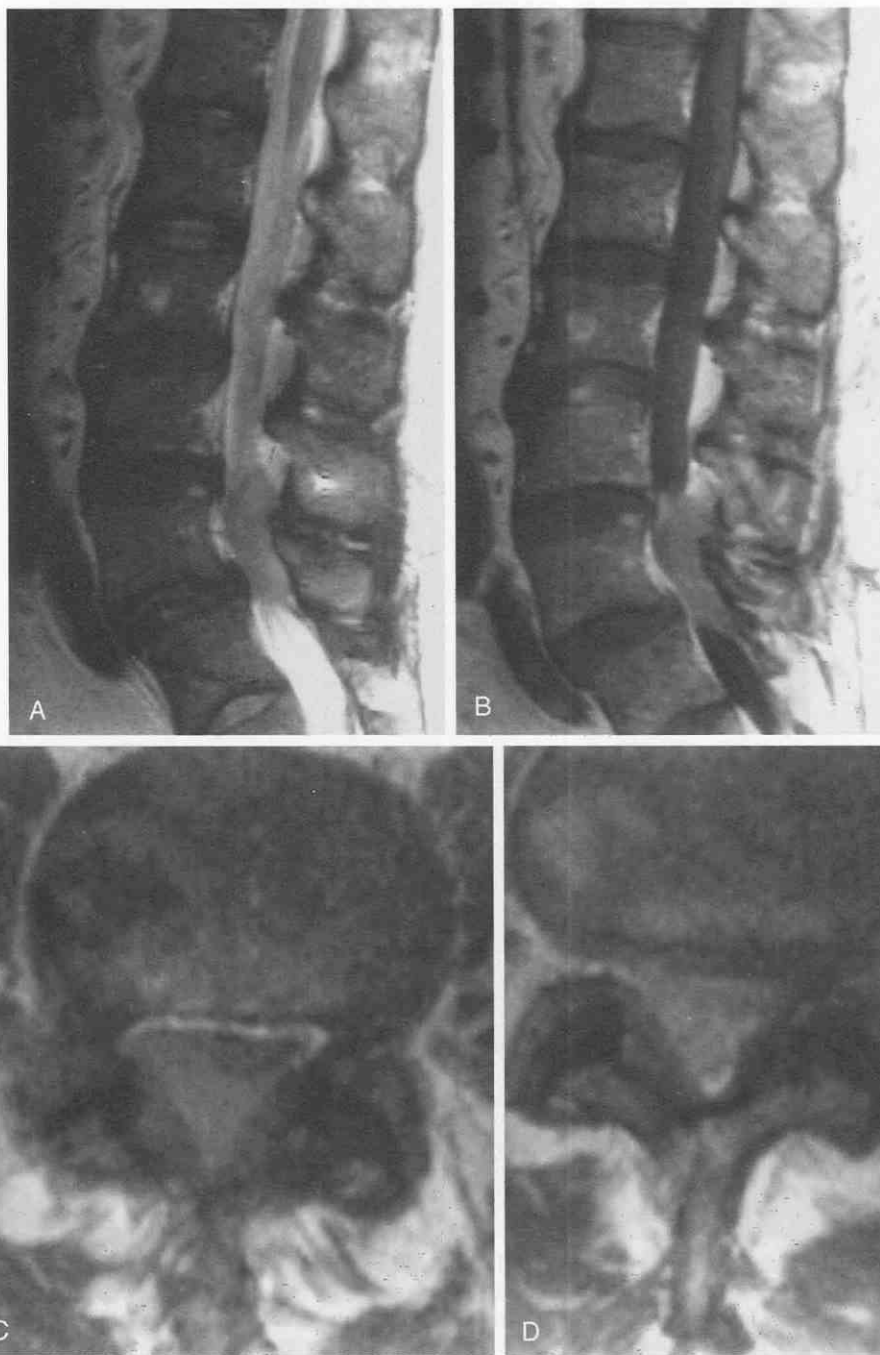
A, Sagittal MRI fast spin-echo T2-weighted image through the lumbar spine. A mass is seen posterior to the L4 vertebral body. The mass was biopsied and proved to be lymphoma. B, MRI sagittal spin-echo T1-weighted image through the lumbar spine following the intravenous administration of Gadoteridol. The mass enhances within the spinal canal. C, Axial T1-weighted image through the mass, which is extradural in location, causing mass effect on the adjacent thecal sac. D, Axial T1-weighted image through the mass, after the intravenous administration of Gadoteridol.
